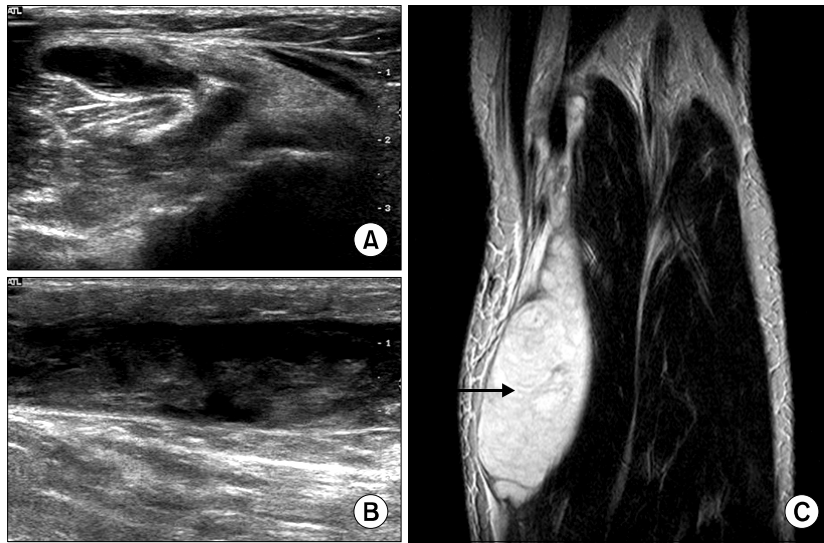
A 46-year-old woman with rheumatoid arthritis and ruptured and dissected baker cyst. Ultrasonogram shows typical location of the baker cyst in the space between the medial head of the gastrocnemius and semembranosus (A). Anechoic dissected baker cyst with internal synovial proliferation demonstrates in the space between the medial head gastrocnemius and superficial fascia (B). Coronal fat suppressed T2-weighted MR image show high signal intensity of baker cyst with rupture and dissection into the space between the medial head gastrocnemius and superficial fascia. There is an extension into the subcutaneous tissue layer (C, arrow).
